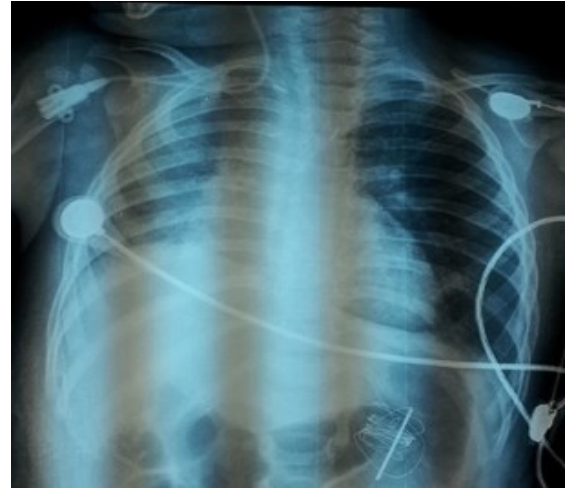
Postoperative day 1, chest x-ray with total atelectasis of the right lung. The patient was intubated
